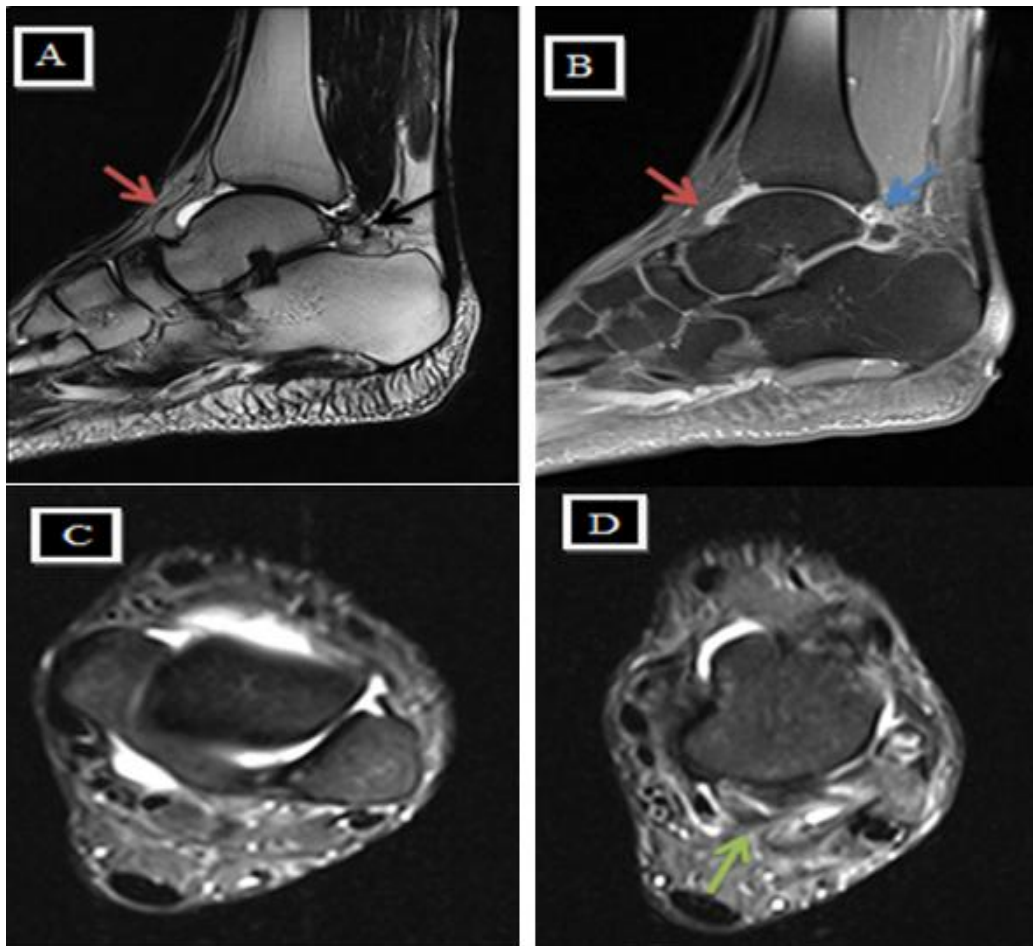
MRI examination, (A) Sagittal T2 WI showed os trigonum (black arrow). (B) Sagittal T2 WI with fat saturation showed os trigonum with surrounding soft tissue edema (blue arrow). Minimal joint effusion is seen (red arrows in A & B). (C) and (D) Axial T2 WI with fat saturation showed mild joint effusion and soft tissue edema posterior to talus (green arrow). Final diagnosis: Posterior ankle impingement
